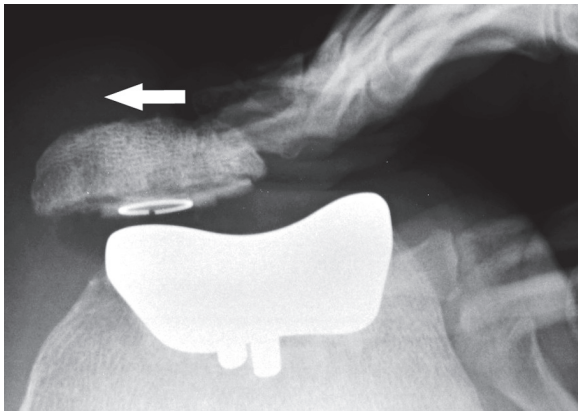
Axial stress radiograph of the left knee showing an iatrogenic medial subluxation of the patella
